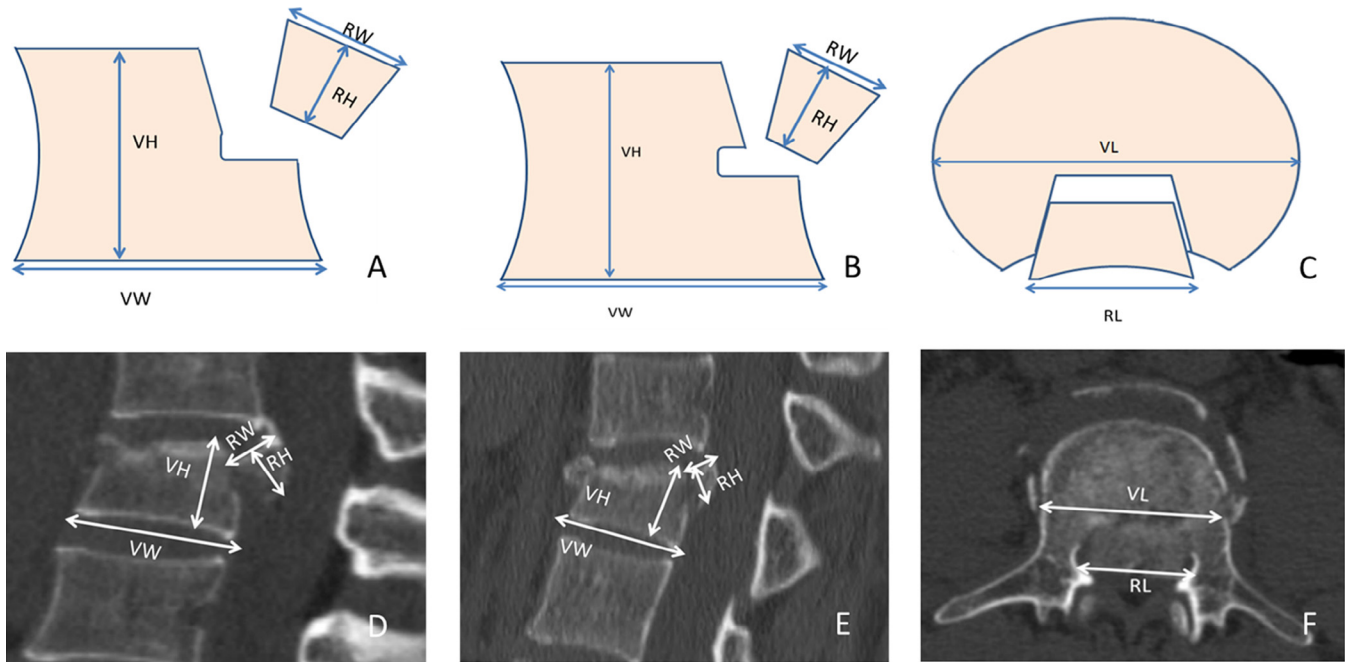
Parameter measurement of RBF. In the transverse plane image, RL is the distance from the left corner to the right corner of the fracture. VL is the maximum length of vertebral body (A, D). In CT sagittal reconstruction image, RW is the distance between posterior corner of cranial end plate and perpendicular from the anterior inferior corner of RBF to the cranial end plate. VW is the maximum width of vertebral body. RH is the vertical distance from the vertex to the cranial end plate. VH is the maximum height of vertebral body (B, C, E, F). The fracture line of RBF goes across the vertex of BF (B, E). The fracture line of RBF goes across the upper surface of BF (A, D). RBF, retropulsed bone fragment; BF, basivertebral foramen; CT, computed tomography.
